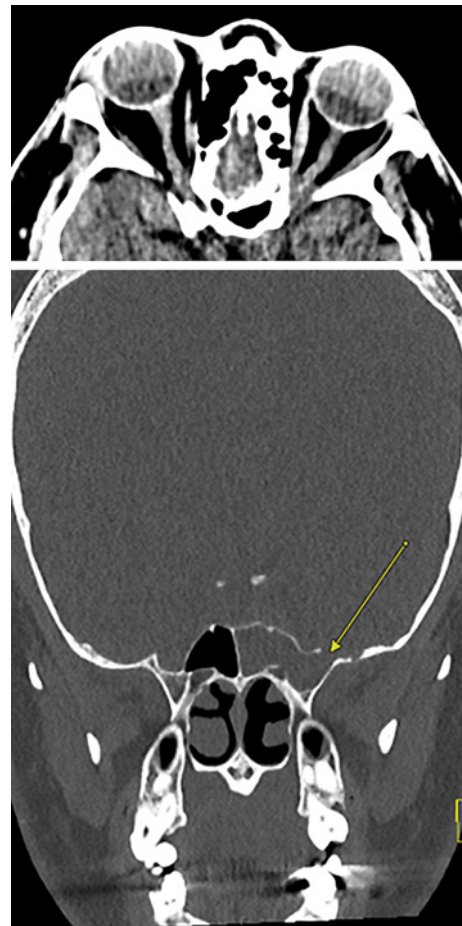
Pre-Op CT head – slight tortuosity of the optic nerves bilaterally and abnormal arachnoid granulations (AGs) along the left middle cranial fossa floor.
